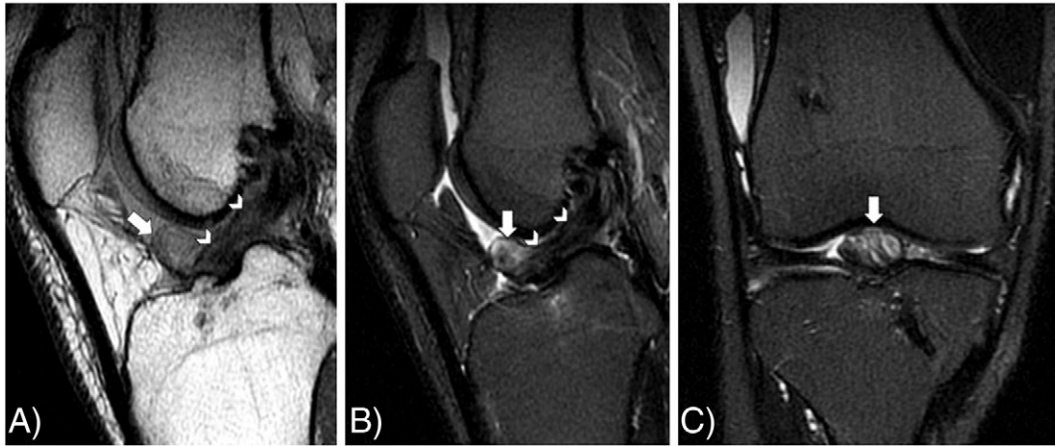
Sagittal T1-weighted (A), sagittal T2 fat-saturated (B), and coronal T2 fat-saturated (C) magnetic resonance image demonstrating the typical heterogeneous soft tissue mass (arrow) anterolaterally within the intercondylar notch adjacent to anterior cruciate ligament graft (arrowheads), indicating a cyclops lesion.
